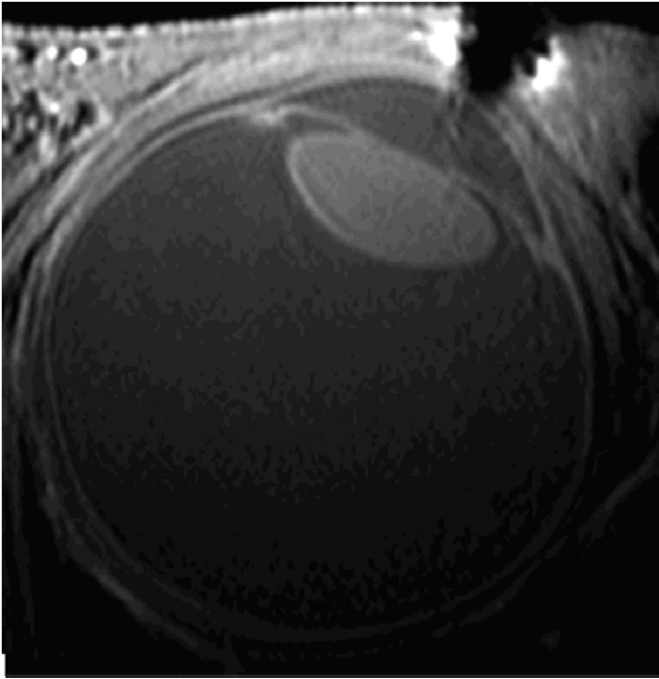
T1-weighted 7 Tesla MR image using an optimised scanning and image processing protocol (Richdale et al., 2009).
